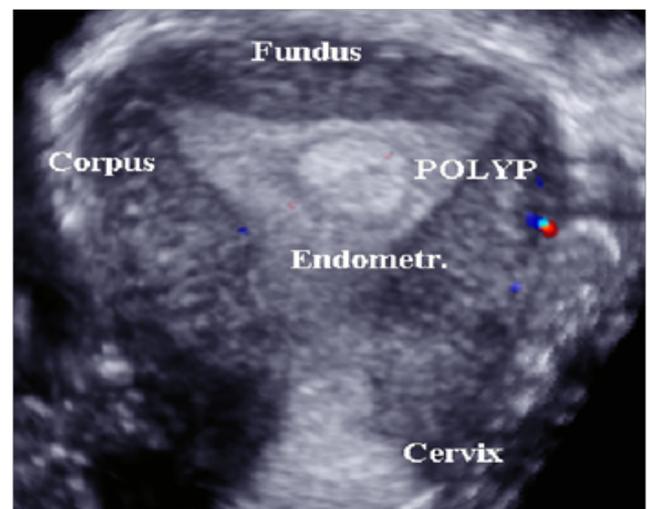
Three- dimensional ultrasound showing endometrial polyp.
